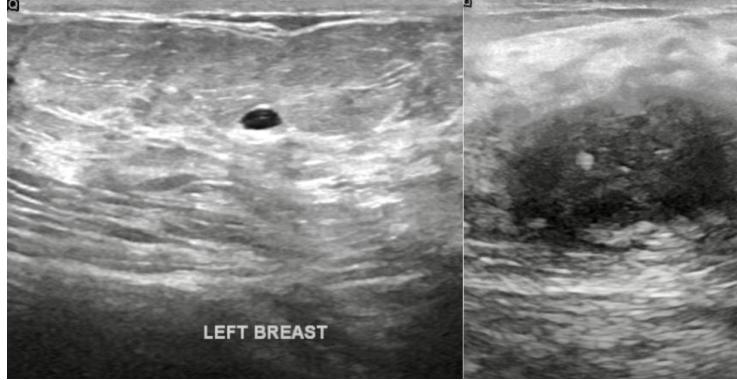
Sample benign and malignant ultrasound images from the ultrasound dataset.
